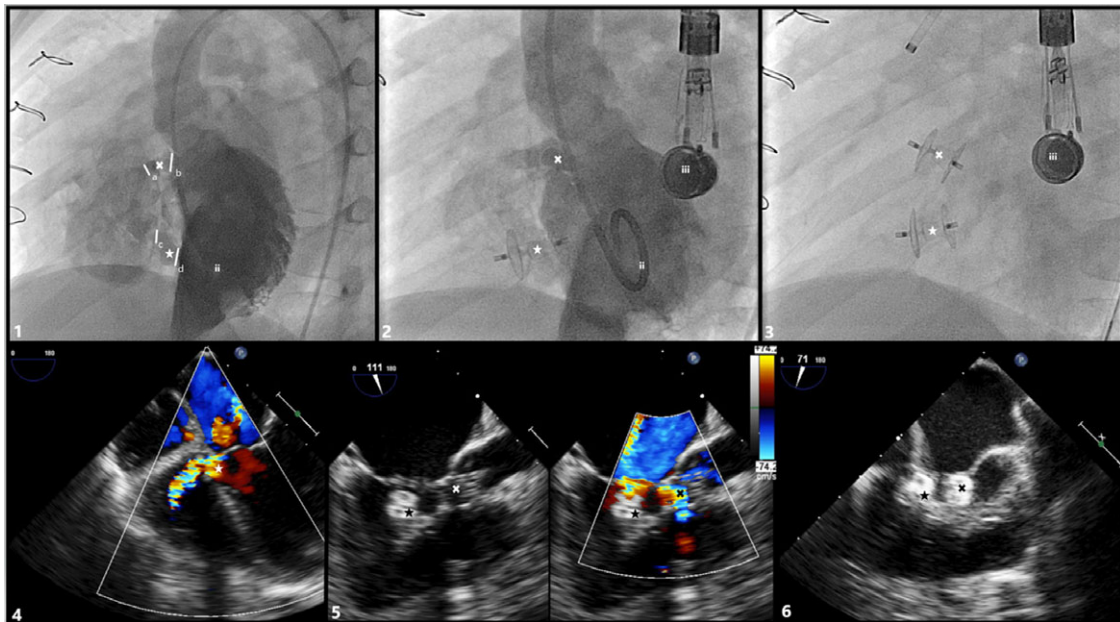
Angiographic and Transesophageal imaging during case: (1) LV angiography (60° LAO, 20° Cranial) using pigtail catheter demonstrating post-operative perimembranous VSD with RV orifice of 3.2 mm (a) and LV orifice of 4.3 mm (b), additional muscular VSD with RV orifice of 3.1 mm (c) and LV orifice of 5.1 mm (d). (2) LV angiography after placement of device in muscular VSD showing shunt through perimembranous VSD. (3) Fluoroscopy showing placement of both closure devices in muscular and perimembranous VSDs. (x) post-operative residual perimembranous VSD. (star) muscular VSD. (ii) pigtail catheter in LV chamber. (iii) transesophageal echocardiography probe.
